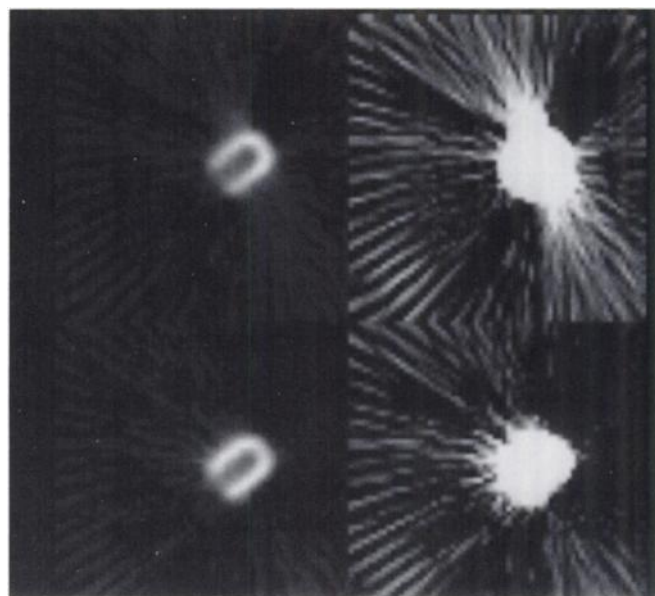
Representative reconstructed transverse slices for Case 2 prior to oblique reorientation. The upper images are uncompensated and the bottom images are attenuation compensated using the CB-CT attenuation map shown in Figure 1. In the right column, the top of the gray scale has been adjusted to 6% of the maximum count to accentuate streak artifacts.
